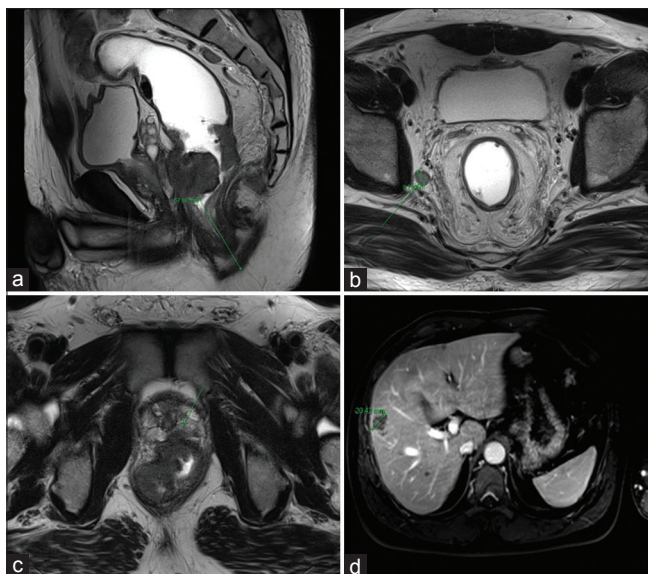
Pelvic magnetic resonance imaging and liver magnetic resonance imaging (a) sagittal view, showing low lying tumor, (b) right lateral pelvic node enlargement, (c) positive circumferential margin at 12 o'clock (d) synchronous solitary liver metastasis
